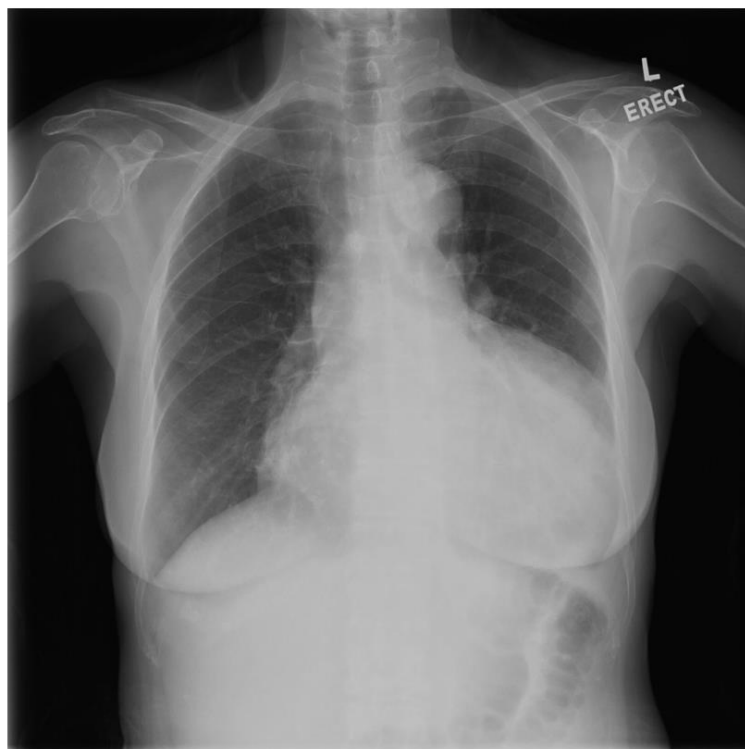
Chest X-ray showing cardiomegaly with globular heart configuration, suggestive of pericardial effusion
